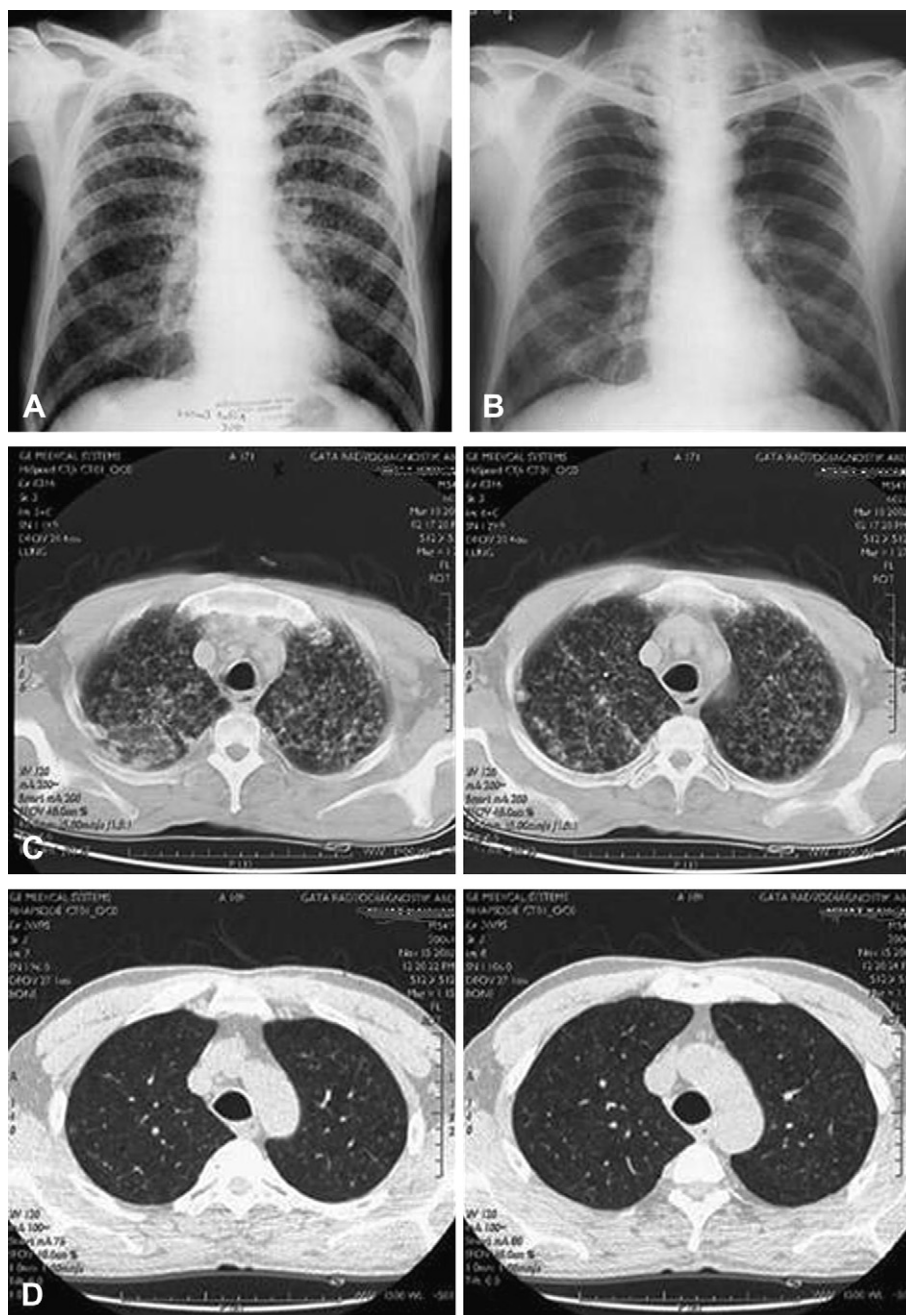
Initial posterior-anterior chest radiography showing bilaterally diffuse reticulo-nodular infiltration (A). Becoming almost normal following a 6-month-anti-tuberculous therapy (B). Initial thorax CT scan image showing bilaterally reticulo-nodular miliary infiltration (C). Almost all infiltrations being cleared at the end of anti-tuberculous therapy (D).
